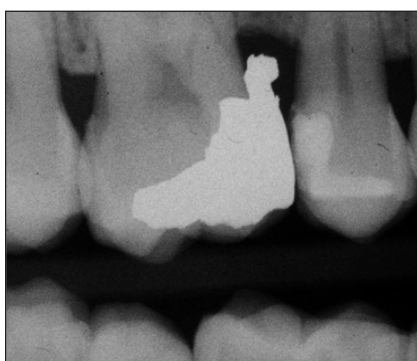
Preoperative radiographic image of tooth #14.
